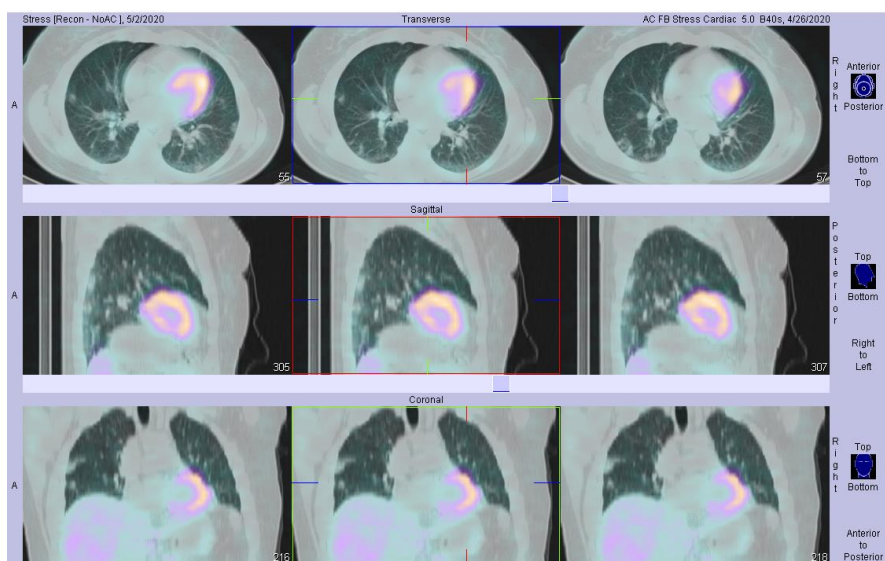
SPECT/CT fused images in lung window showed multifocal, bilateral and peripheral ground glass opacities throughout lungs with subtle background uptake of Tl-201.
